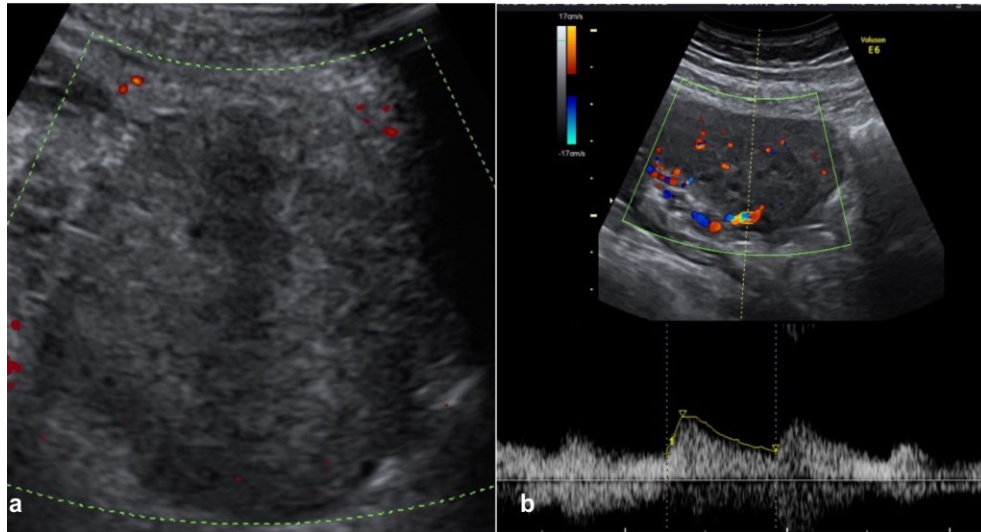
a) Ovarian torsion, late phase. Hemorrhagic necrosis. Hypoechoic mass with absent arterial Doppler flow; b) Partial arterial perfusion on early phase of the ovarian torsion
